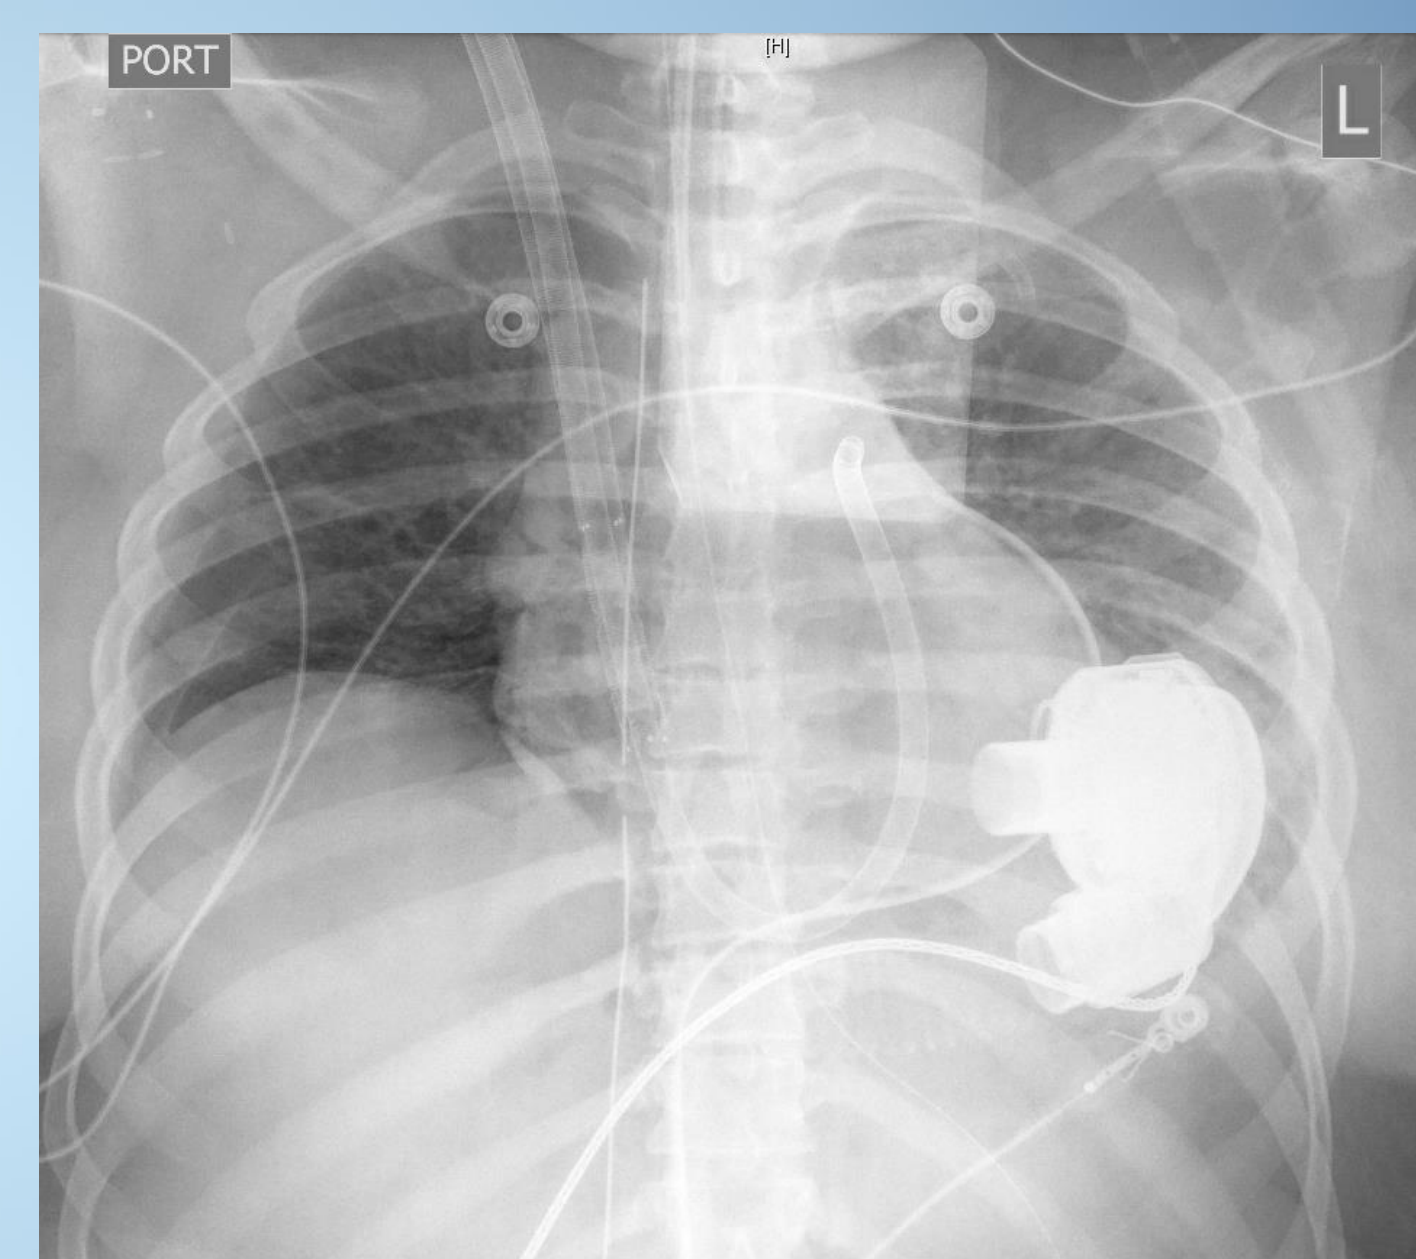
Post-operative chest x-ray with HeartMateIII® LVAD and ProtekDuo® RVAD
